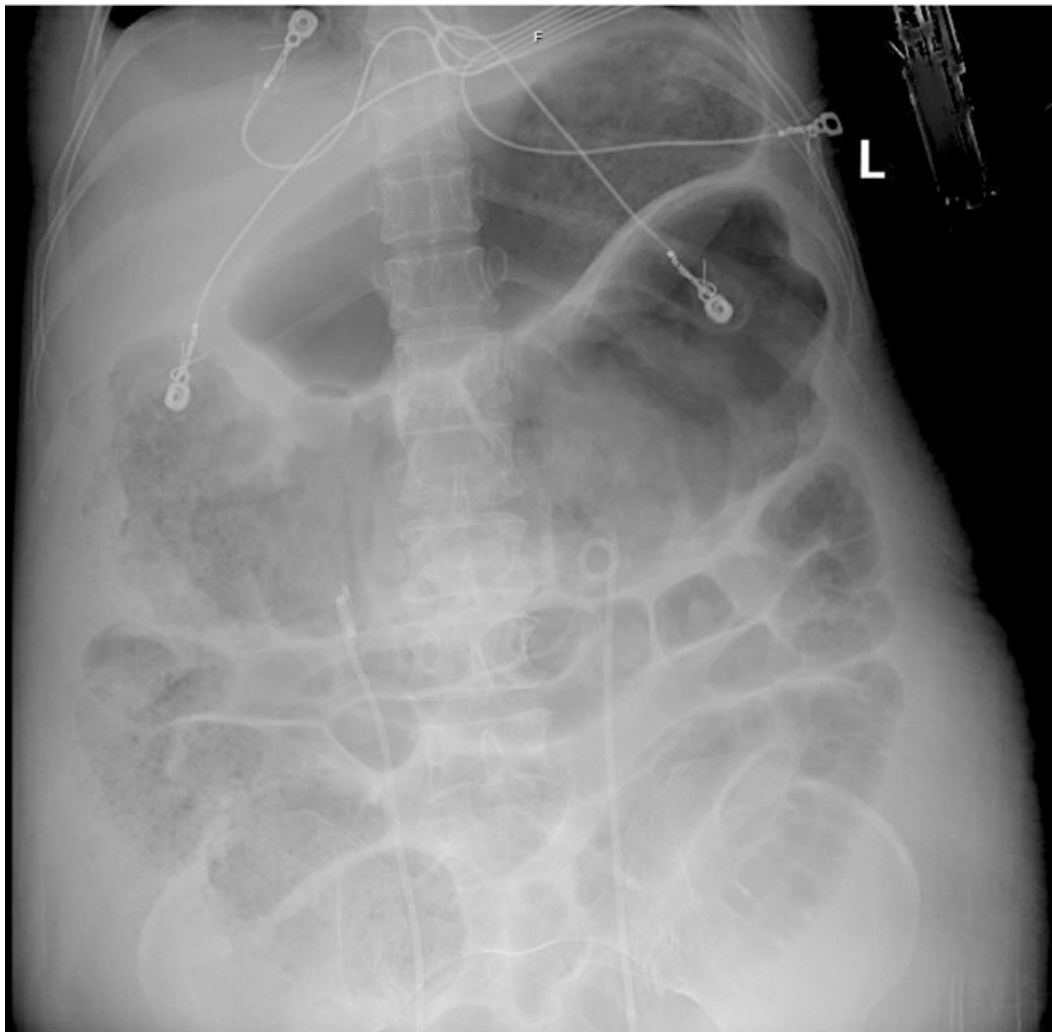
Radiographic appearance of toxic megacolon in a patient with *C. difficile* enterocolitis.
